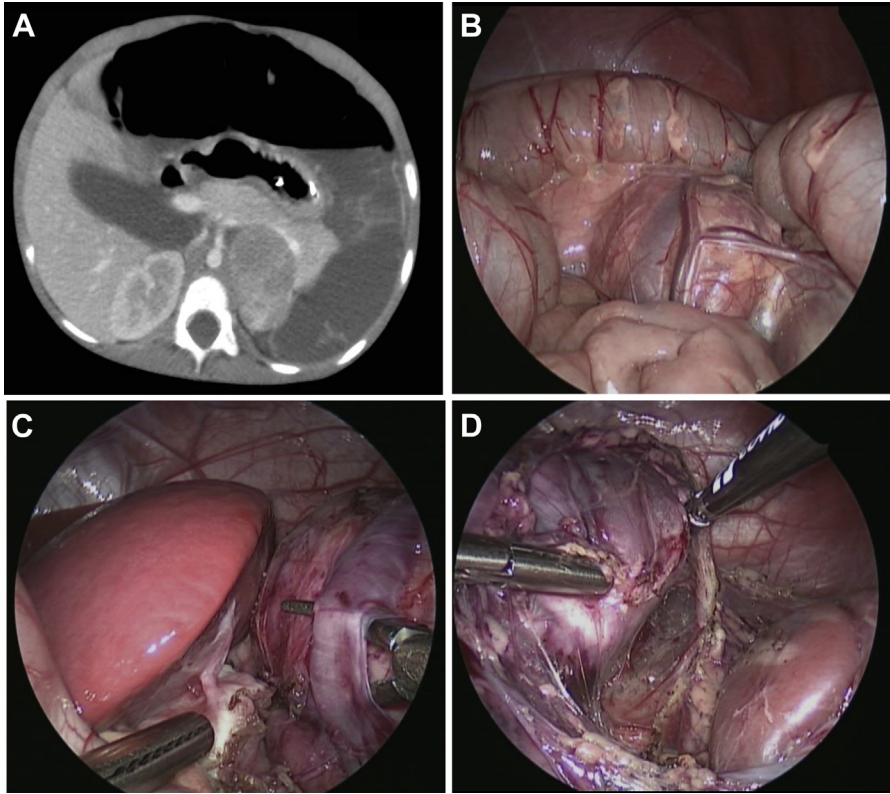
Laparoscopic resection of a left adrenal neuroblastoma. (A) Preoperative computed tomography scan. (B) View of the tumor through the colon mesentery. (C) Isolation of the adrenal vein. (D) Elevation of the tumor from the left upper quadrant. (Courtesy of Harold N. Lovvorn, III, M.D).
